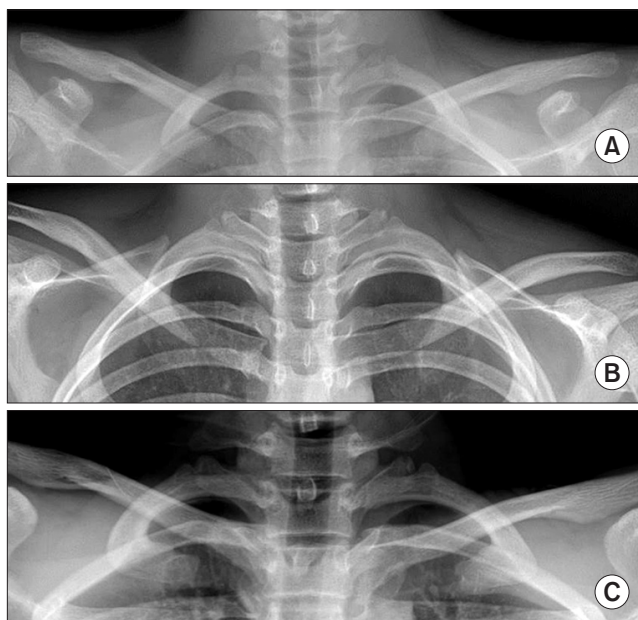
The radiographic changes can be absent in clavicle antero-posterior view (A), lordotic view (B), and left clavicle was inferior migration in Hobb's view (C).
